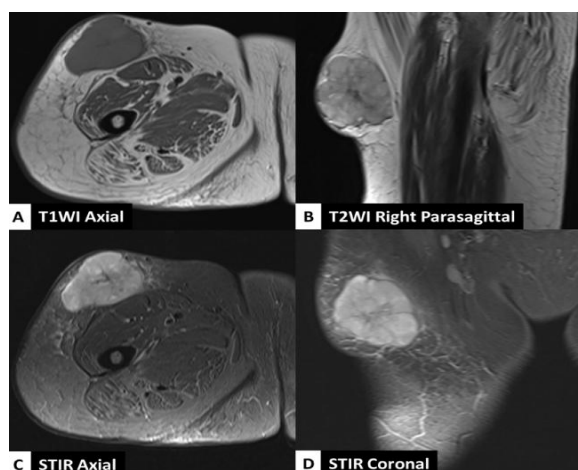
MRI of Right Thigh.
